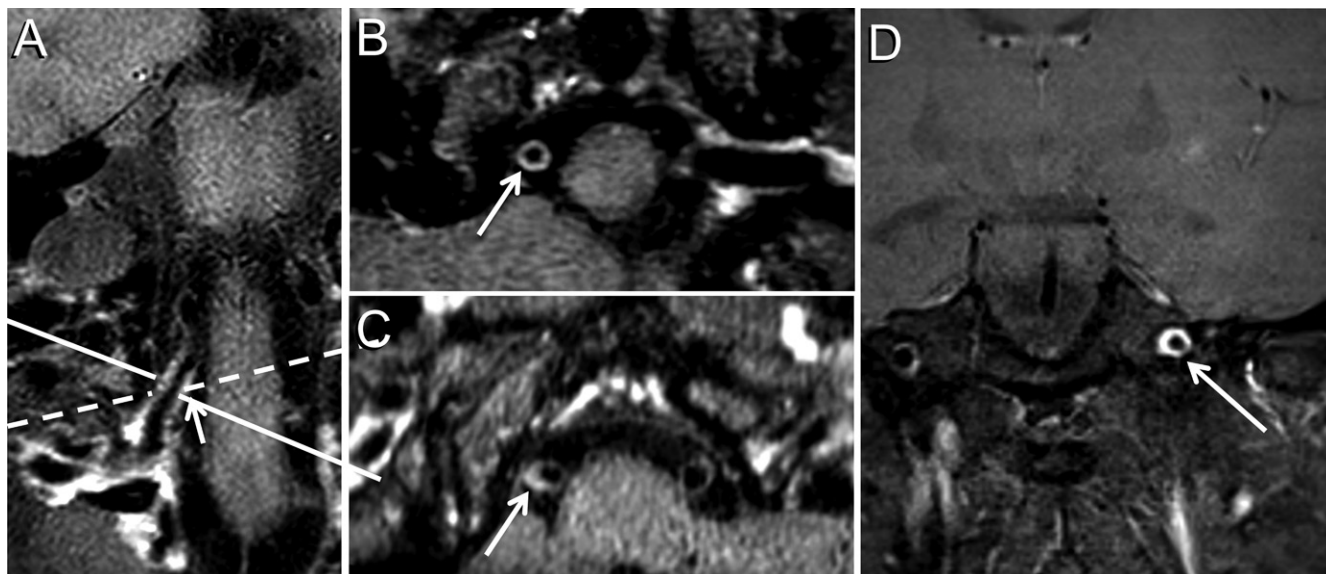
Venous plexus enhancement mimicking vasculitis or atherosclerotic plaque. (A) Coronal long-axis postcontrast vessel wall (VW) MRI scan of the right vertebral artery in a 32-year-old woman without cardiovascular risk factors shows thick enhancement along the wall from the extradural venous plexus that follows the vessel as it enters the intracranial compartment. (B) Short-axis reconstructed image (acquired resolution, 0.5 mm³) through the right vertebral artery (solid line in A) shows concentric thickening and avid enhancement due to partial volume averaging of the wall and plexus (arrow in B). (C) Oblique orientation of the reconstructed image through the right vertebral artery (dashed line in A) exaggerates the lateral wall thickness of the artery (arrow in C), resembling eccentric wall thickening as seen with plaque. Venous plexus enhancement surrounding the petrous internal carotid artery (ICA) mimicking vasculitis in a 16-year-old girl suspected of having focal cerebral arteriopathy. (D) Postcontrast VW MRI scan shows partial collapse of the left ICA due to severe stenosis at its terminus, resulting in compensatory expansion of the venous plexus within the petrous carotid canal surrounding the vessel and resembling vasculitis (arrow).
